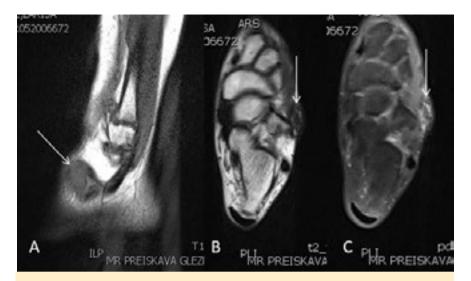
Companion case No. 3. A 10-year-old girl with a palpable lump. Sagittal MRI of the right ankle (A) demonstrated a hypointense subcutaneous soft-tissue mass (arrows) with a T1 isointense signal to muscle on a sagittal image (A), moderately T2 hypointense (B), and mildly hyperintense heterogenous PDFS (C) signals on axial images. A heterogenous and moderately-hypointense signal on fluid-sensitive sequences (B, C) represented possibly a chronic lesion with fibrotic changes or hemosiderin after minor bleeding into the lesion.
